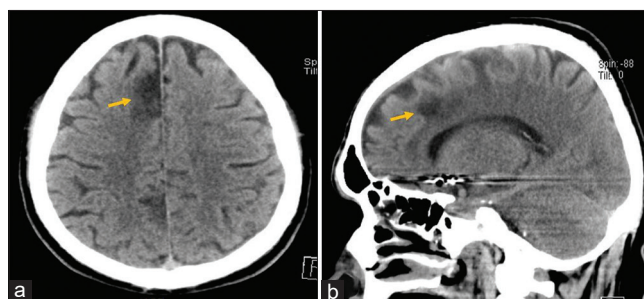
(a) Axial plane showing the right frontal parasagittal ischemic area. (b) Sagittal plane showing superior frontal gyrus and cingulate gyrus ischemic lesions. CT brain without contrast axial and sagittal view showing right frontal parasagittal area hypodensity most likely representing acute ischemic stroke.
